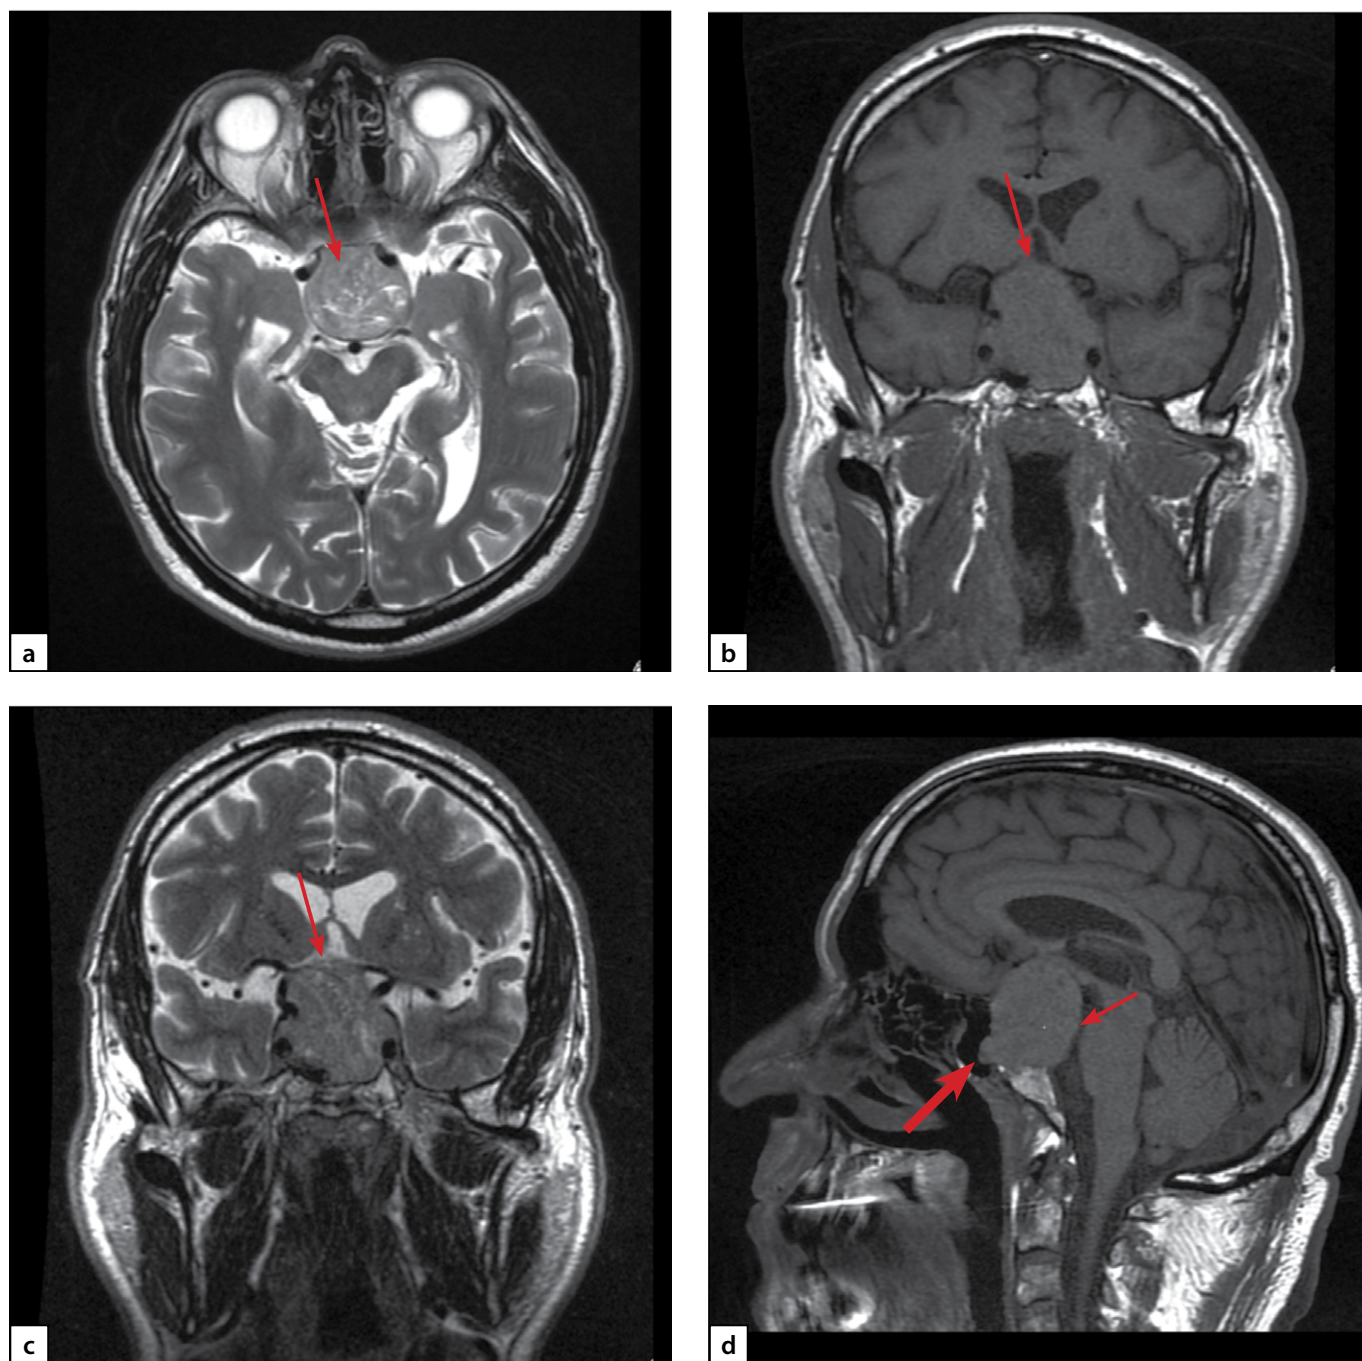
Brain MRI of patient G. Pituitary macroadenoma with supra-, infra- and retro- parasellar (D, S,) extension (Knosp IV):
